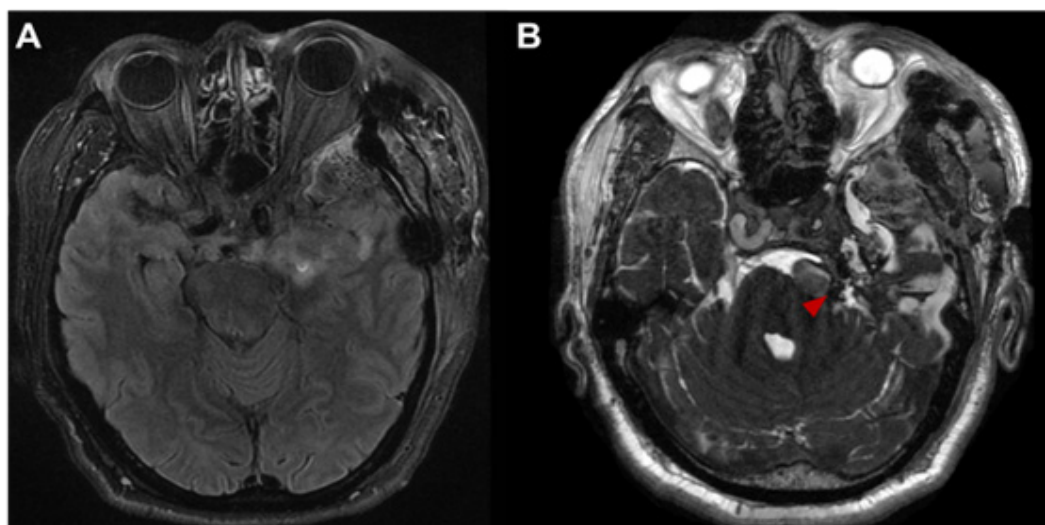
Brain MRI was obtained immediately after the surgery. A) In the axial view of T2-weighted imaging, the left side hippocampus had mild edema which was probably ascribed to temporal lobe retraction intraoperatively. B) In the series of CISS, It was noticed that low-signal Teflon prosthesis wrapped around BA in the left cerebellopontine angle (arrowhead). (MRI = magnetic resonance imaging; CISS = constructive interference in steady state, BA = basilar artery).
